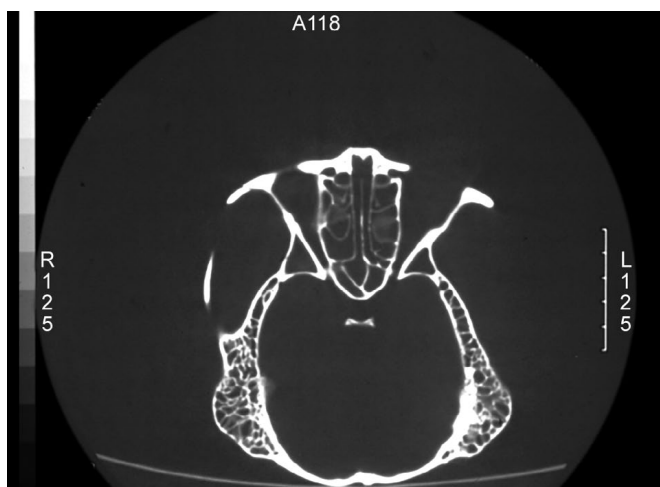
An axial computed tomography scan of a chimpanzee cranium. Note the extensive system of ethmoid air cells. This anatomic pattern is similar to the human condition.
